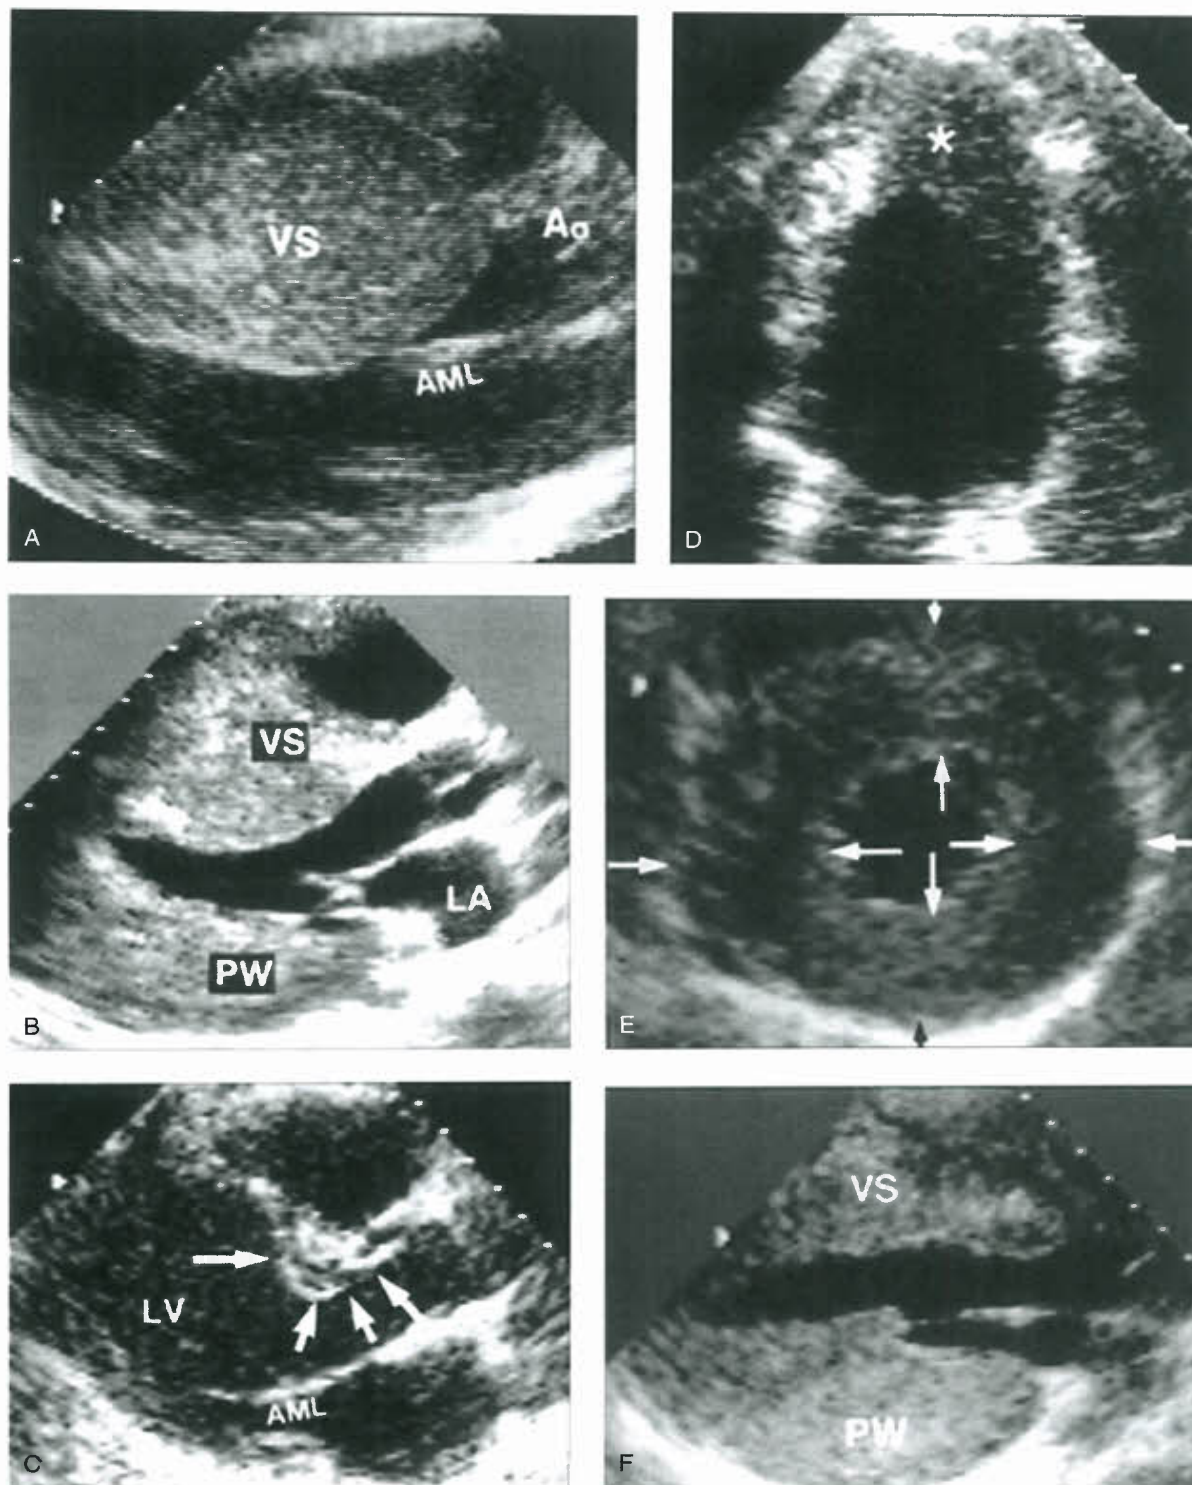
Patterns of LVH in HCM. Heterogeneous distribution and extent of LV wall thickening by echocardiography. A: Massive asymmetrical hypertrophy of VS with thickness >50 mm. B: Septal hypertrophy with distal portion considerably thicker than proximal region. C: Hypertrophy confined to proximal septum just below aortic valve (arrows); D: Hypertrophy localized to LV apex (asterisk)—that is, “apical HCM”; E: Relatively mild hypertrophy in symmetrical pattern showing similar or identical thicknesses within each segment (paired arrows); F: Inverted pattern with posterior free wall (PW) thicker (40 mm) than anterior VS. Calibration marks = 1 cm. Ao, aorta; AML, anterior mitral leaflet; LA, left atrium. (Reproduced from, Maron MS, Maron BJ, Harrigan C, et al. Hypertrophic cardiomyopathy phenotype revisited after 50 years with cardiovascular magnetic resonance. *J Am Coll Cardiol* 2009;54:220–228, with permission of Elsevier).
